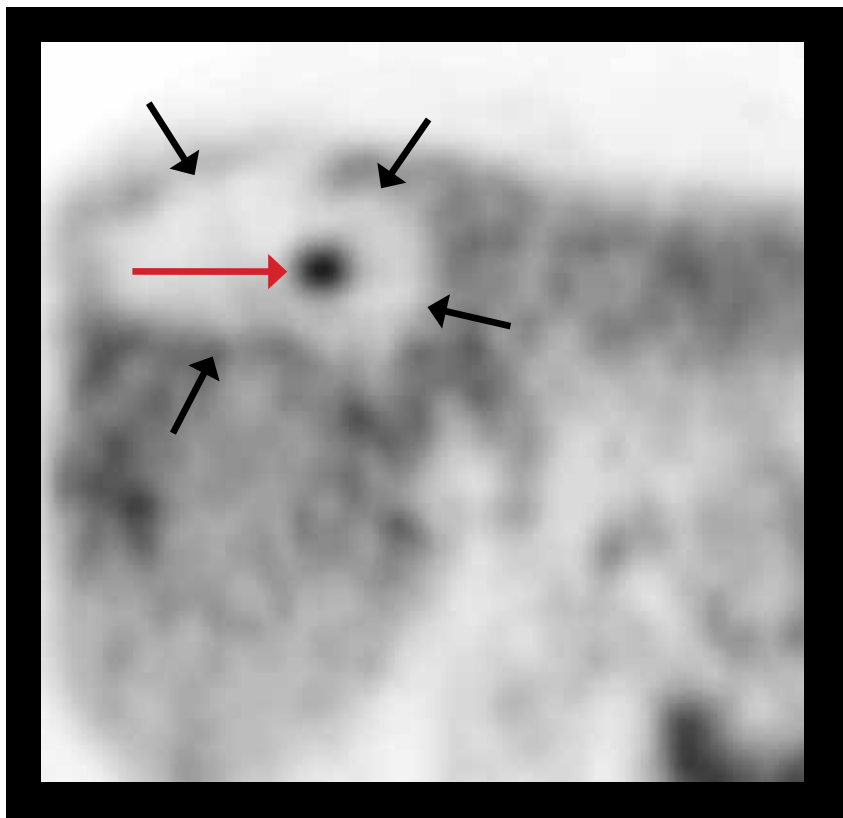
PET-only image acquired after infusion of  $^{13}\text{N-NH}_3$  shows perfusion activity surrounding the non-perfused hypometabolic ablation margin (black arrows), which in turn surrounds the tumor (red arrow) (containing persistent high activity due to trapped  $^{18}\text{F-FDG}$  within the tumor despite microwave ablation).
